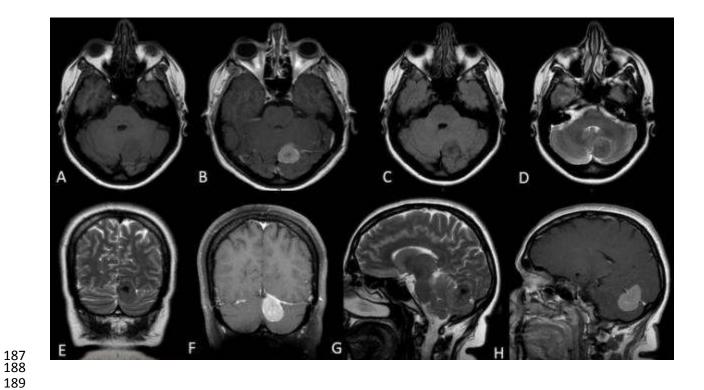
Preoperative MR imaging for a 36-year-old woman with tentorial meningioma. MRI demonstrated a large left medial tentorial meningioma extending along tentorium with supra and infra- tentorium components, causing significant mass effect on these structures without early signs of hydrocephalus. Axial (A) T1, (B) enhanced T1, (C)FLAIR, (D) T2; coronal (E) T2, (F) enhanced T1; sagittal (G)T2, (H) enhanced T1 MRI.
